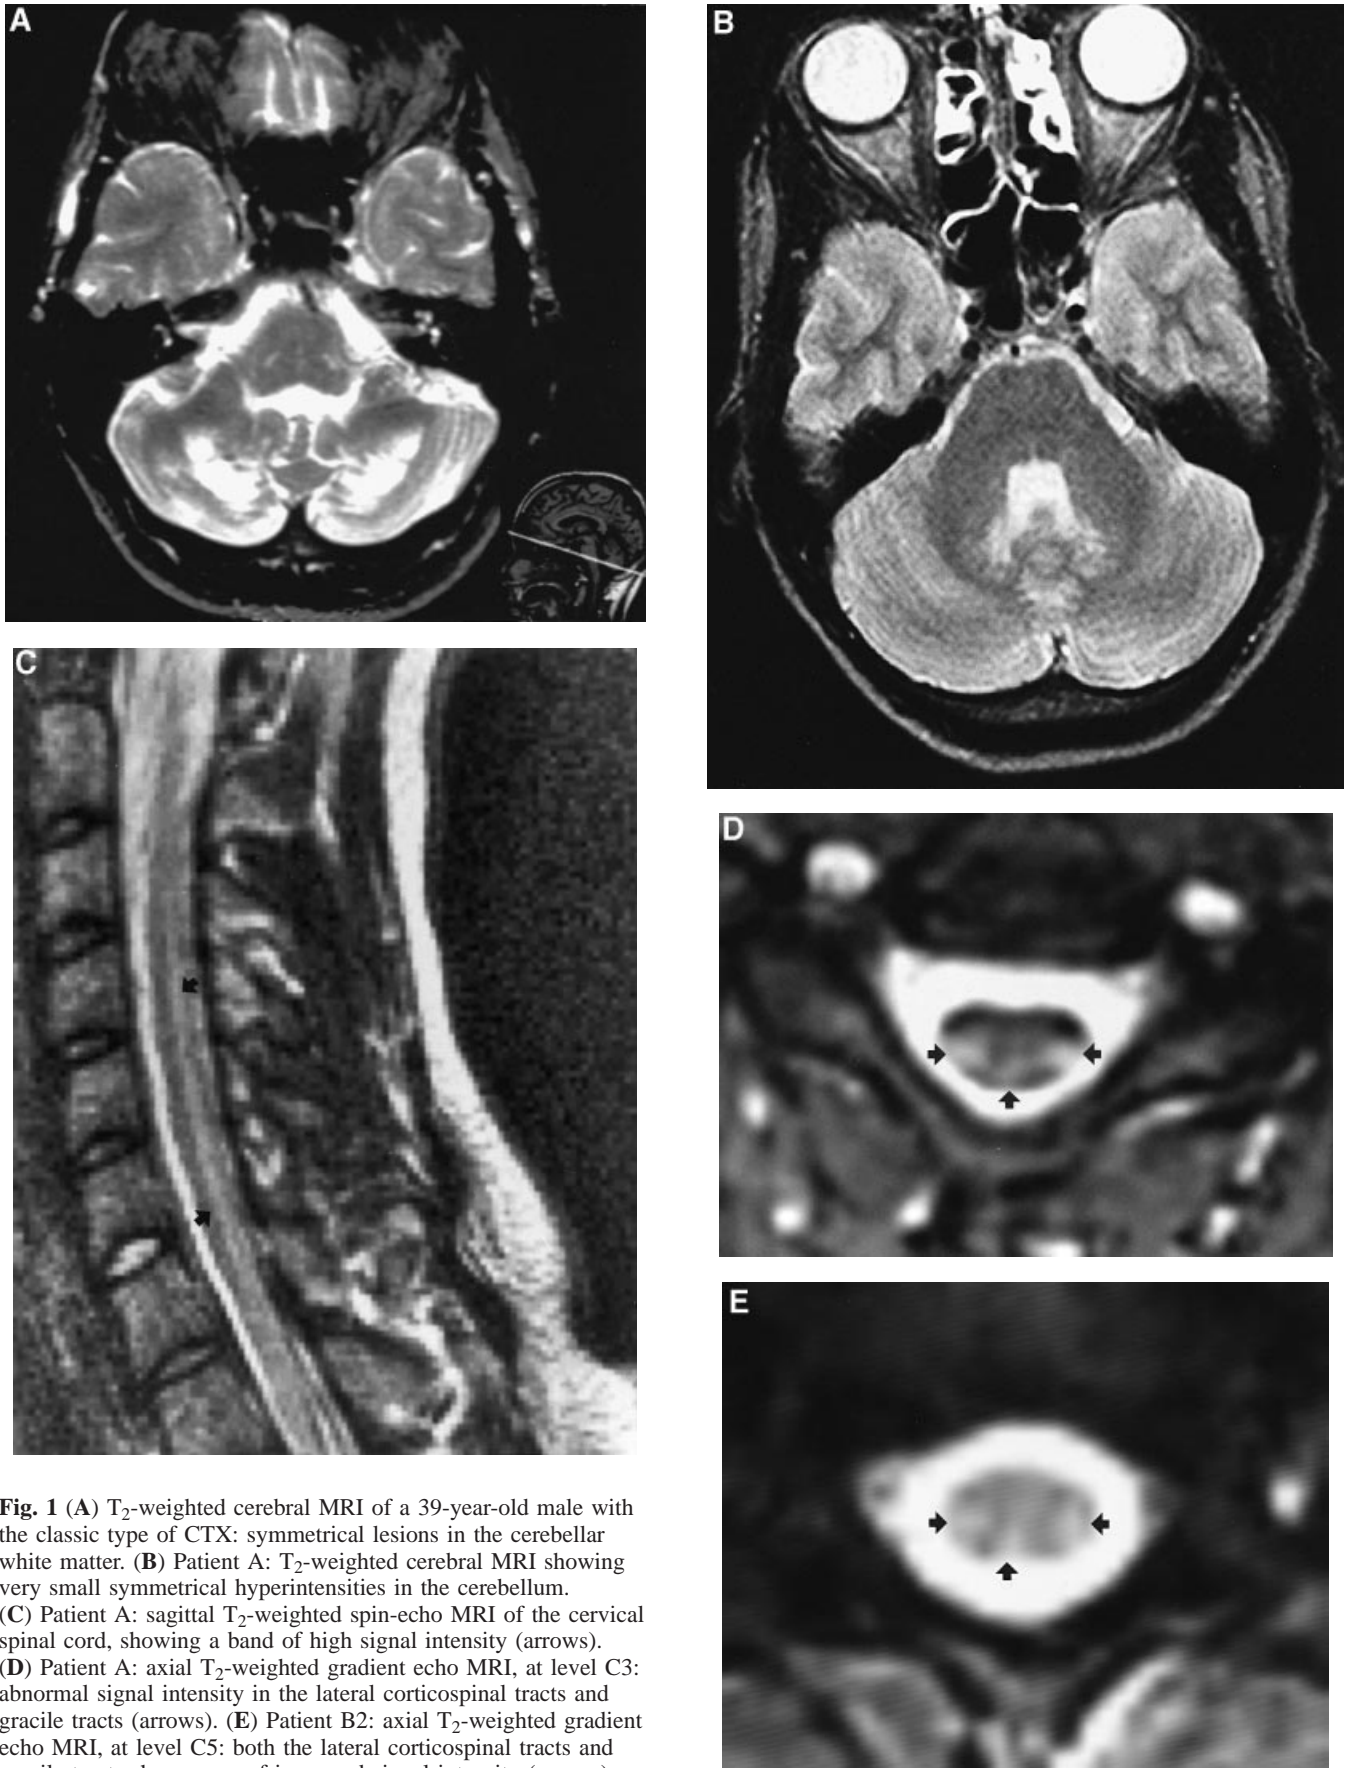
(A) T₂-weighted cerebral MRI of a 39-year-old male with the classic type of CTX: symmetrical lesions in the cerebellar white matter. (B) Patient A: T₂-weighted cerebral MRI showing very small symmetrical hyperintensities in the cerebellum. (C) Patient A: sagittal T₂-weighted spin-echo MRI of the cervical spinal cord, showing a band of high signal intensity (arrows). (D) Patient A: axial T₂-weighted gradient echo MRI, at level C3: abnormal signal intensity in the lateral corticospinal tracts and gracile tracts (arrows). (E) Patient B2: axial T₂-weighted gradient echo MRI, at level C5: both the lateral corticospinal tracts and gracile tracts show areas of increased signal intensity (arrows).
